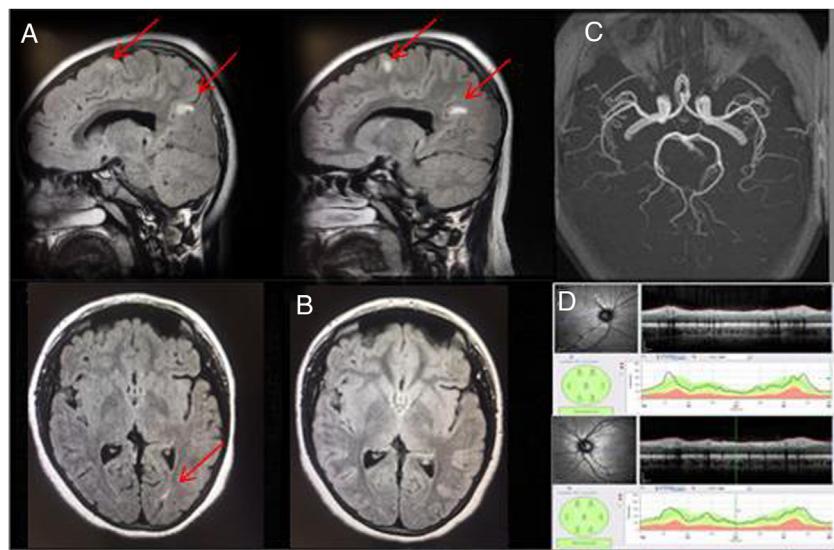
Supplementary tests of patient 2 (AOJ) (A) MRI sagittal and axial images with FLAIR sequence with gadolinium showing hyperintense lesions in juxtacortical white matter suggesting demyelinating disease. (B) MRI gadolinium in T2 showing production and/or disappearance of some of the hyperintense lesions at month 3. (C) Angio-MRI images without alterations. (D) OCT-SD of the retina nerve fiber layer without alterations.
